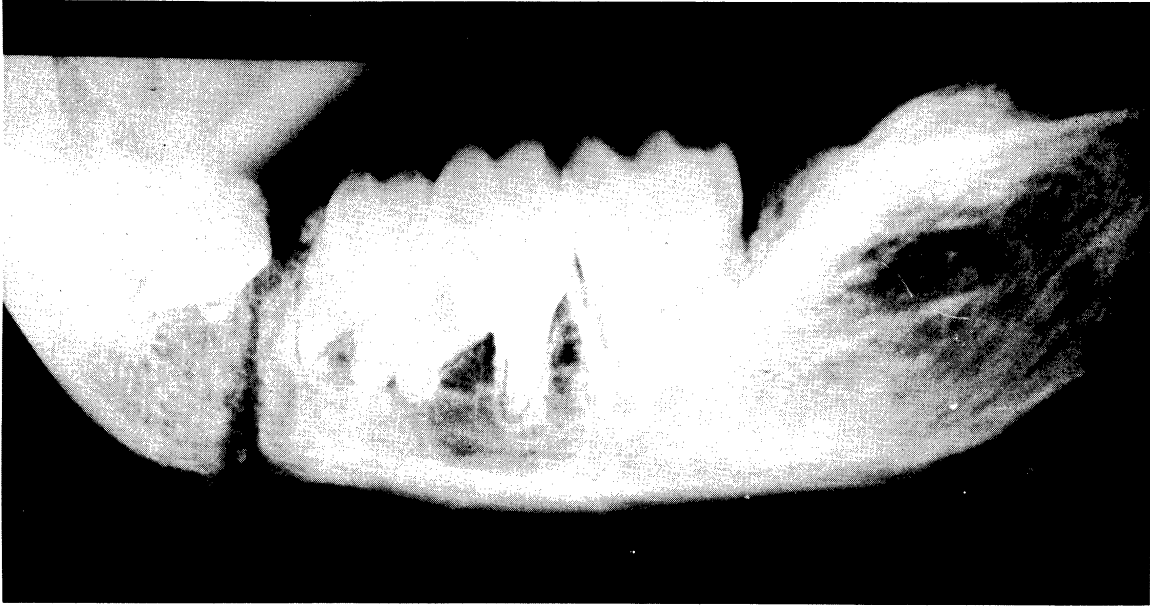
Radiographic evidence of nonunion six weeks after incorporation of adhesive to the fracture site.
